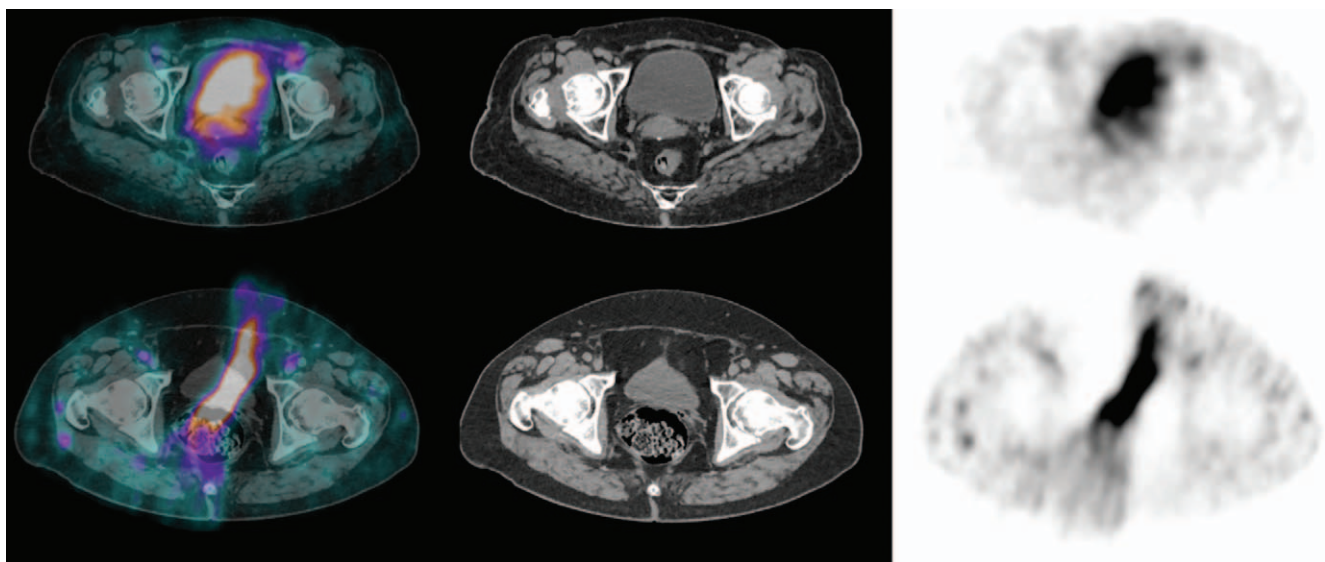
Early phase bone SPECT acquisitions and corresponding CT. Top line: acquisition using the (16–8–2) protocol. Activity is seen in the bladder, uterus, and left iliac vessels. No clear helical artefact is visible; bottom line: acquisition using the previously used acquisition protocol (32–8–1) with a marked distortion of the bladder on the SPECT part of the acquisition.
